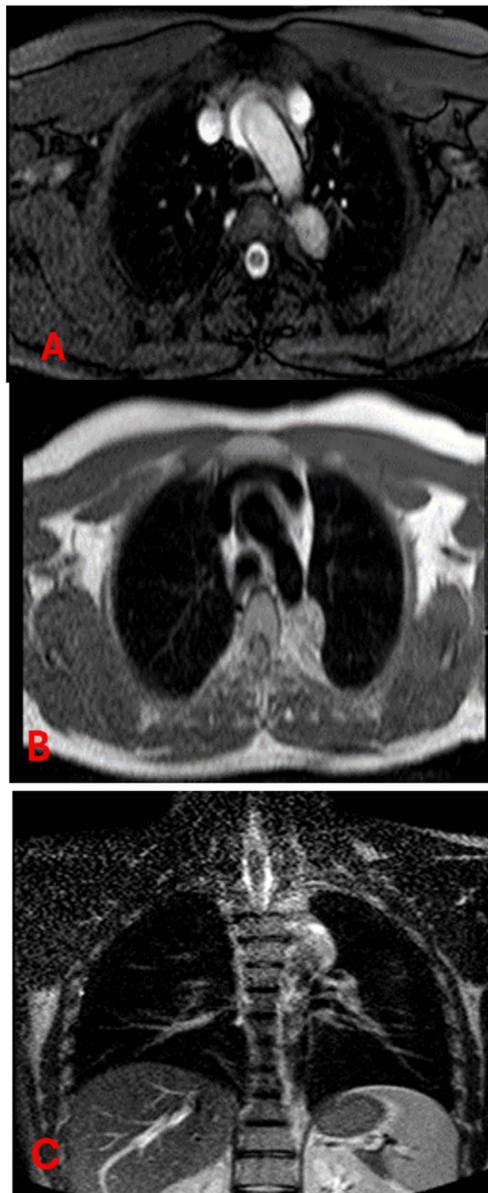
Chest MRI showing left posterior paraspinal soft tissue mass (A = T2 image; B = T1 Image; C = coronal cut view).
